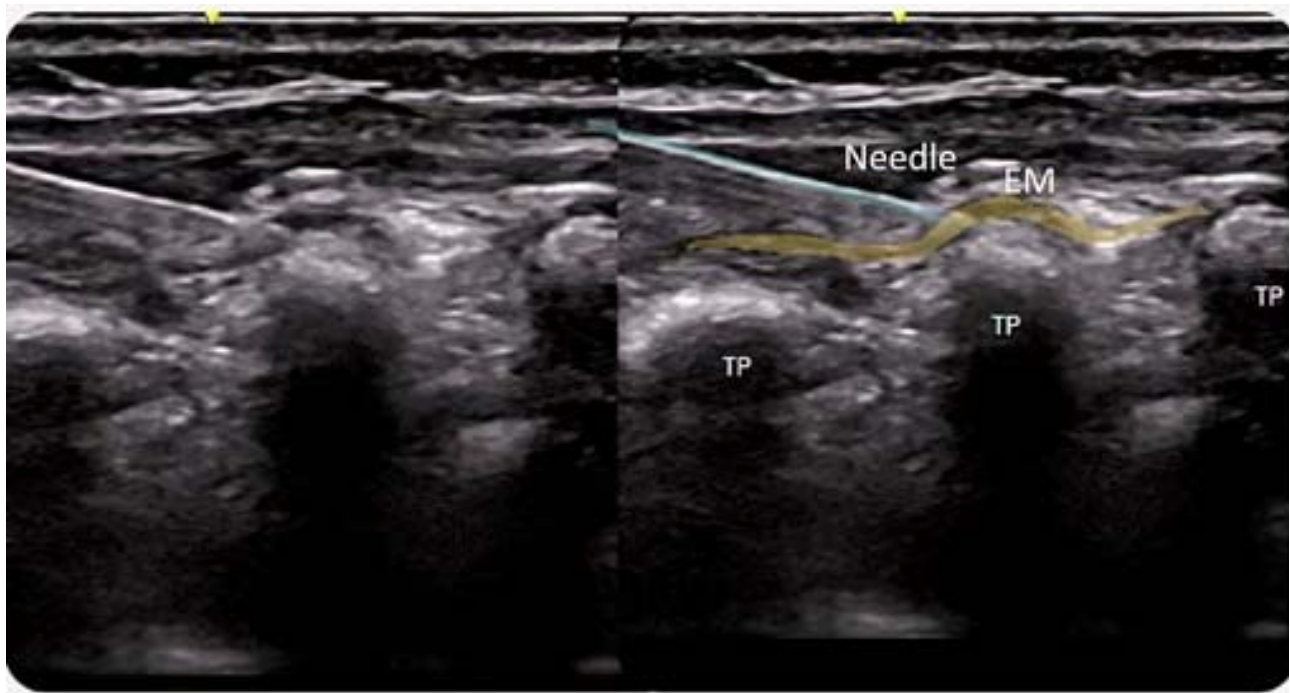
Ultrasound demonstrating needle to ESP at the level of T6 (cranial- caudal orientation)
